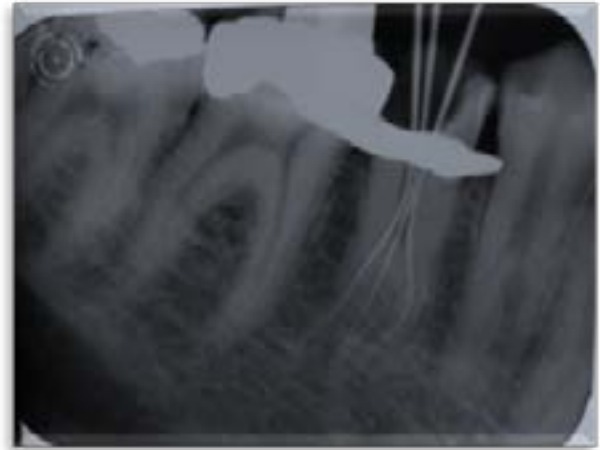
Working length radiograph, which shows three roots.
